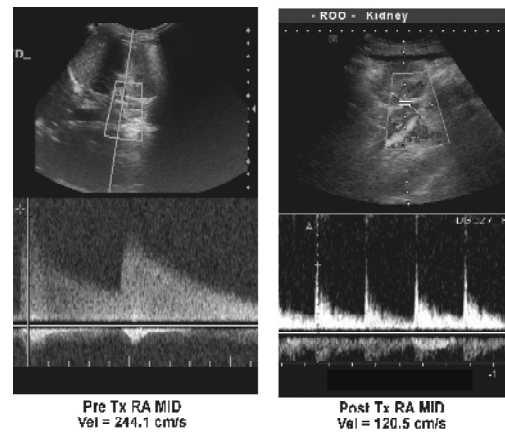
Colour doppler of right renal artery- pre and post renal autotransplantation
